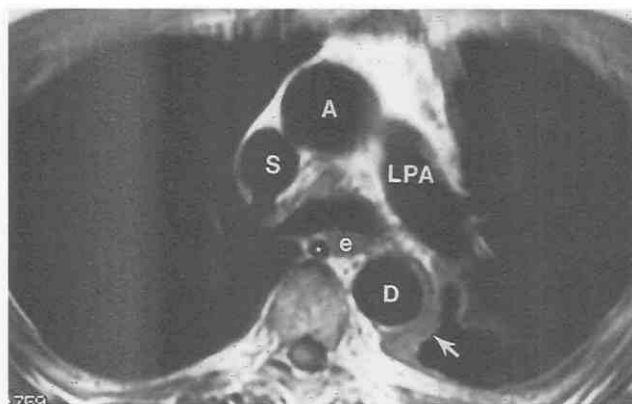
Axial MR image of the left pulmonary artery in a patient with mesothelioma of the left hemithorax. Note soft tissue mass (arrow) encasing the descending aorta. A, ascending aorta; D, descending aorta; e, esophagus; LPA, left pulmonary artery; S, superior vena cava. The asterisk indicates the azygos vein.
